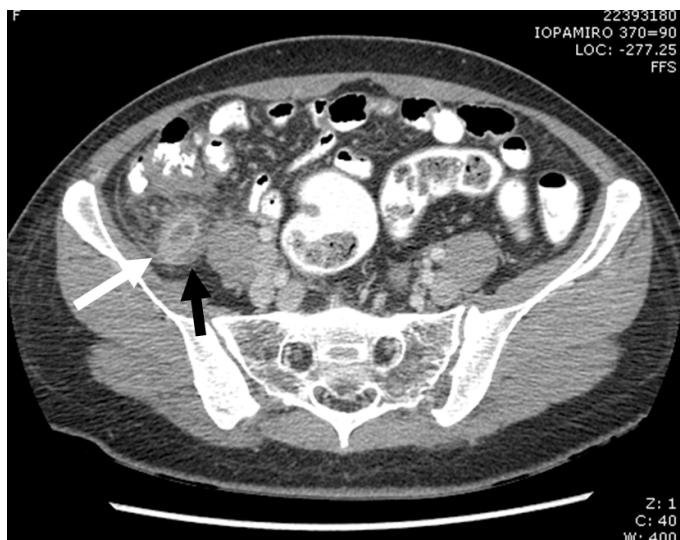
Axial enhanced CT scan of patient with acute gangrenous appendicitis, showed fluid-filled distension and enlargement of appendix with shaggy appendiceal wall (white arrow). Periappendiceal fat strandings were seen. (black arrow)
